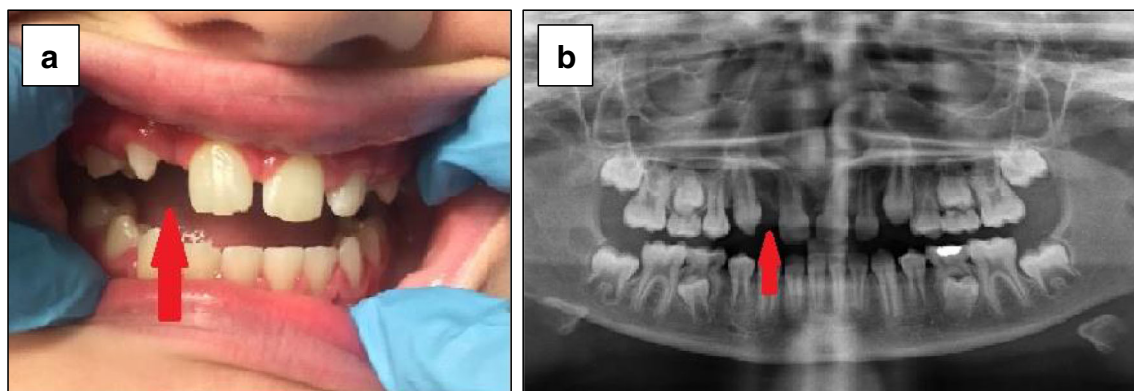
Image (A) and radiograph (B) of excessive spacing in the dentition of an 11-year-old child and the dental radiograph confirming the congenital absence of the right maxillary lateral incisor highlighted by red arrow
